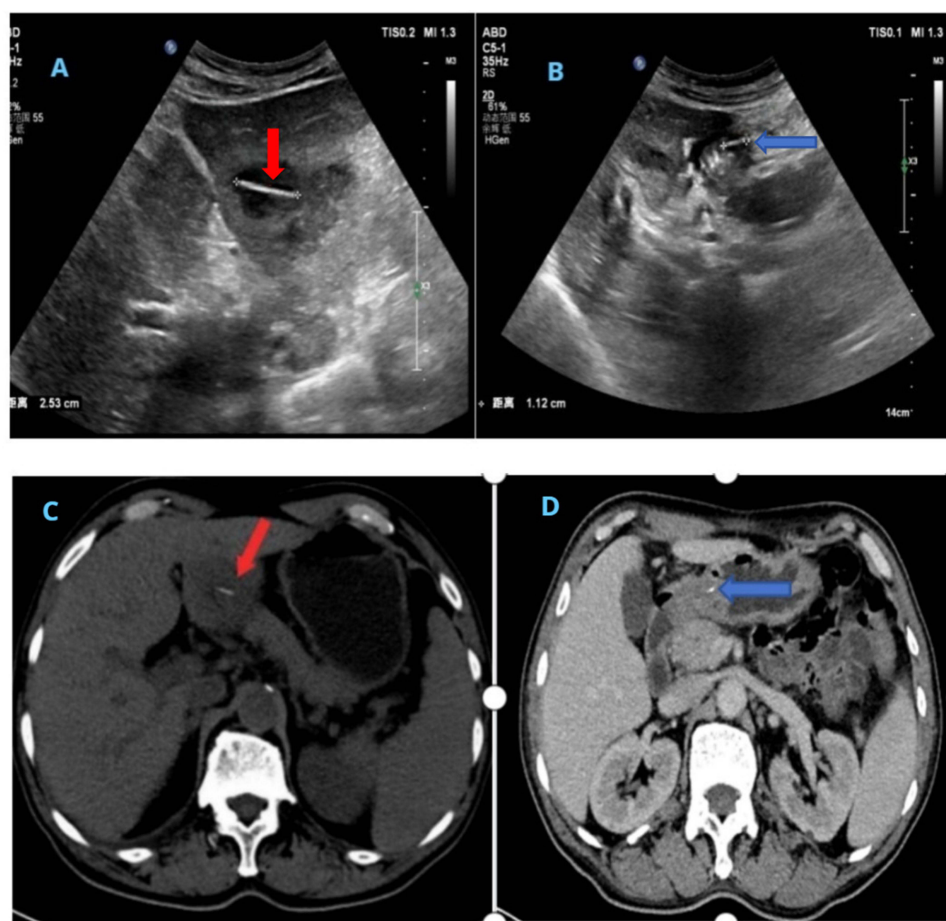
(A and B) Abdominal ultrasonography findings. (A) A hyperdense linear body (red arrow) was located in the left lobe of the liver; (B) A hyperdense linear body was found in the stomach wall (blue arrow). (C and D) Abdominal contrast-enhanced computed tomography findings. (C) A hyperdense linear body (red arrow) was found in the liver abscess. (D) A hyperdense linear body was found in the stomach wall (blue arrow).
